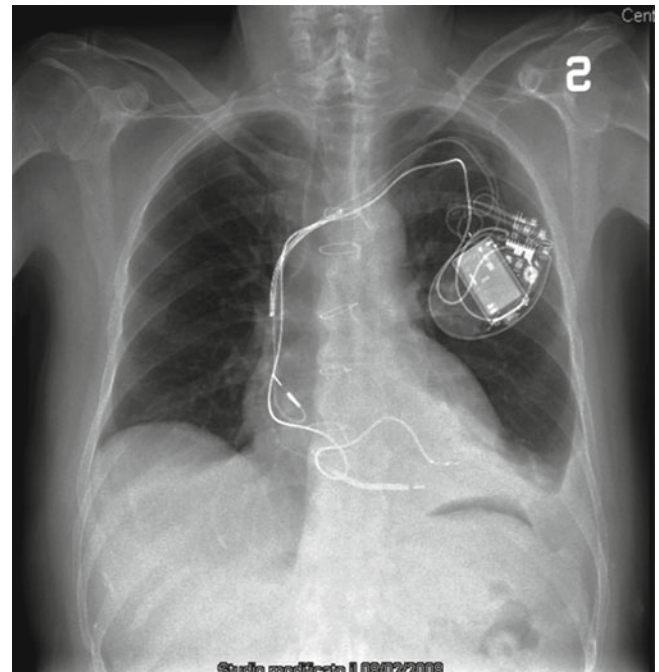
X-ray analysis of the patient shown in Fig. 7.5 shows the absence of the apical calcification after the surgical procedure
